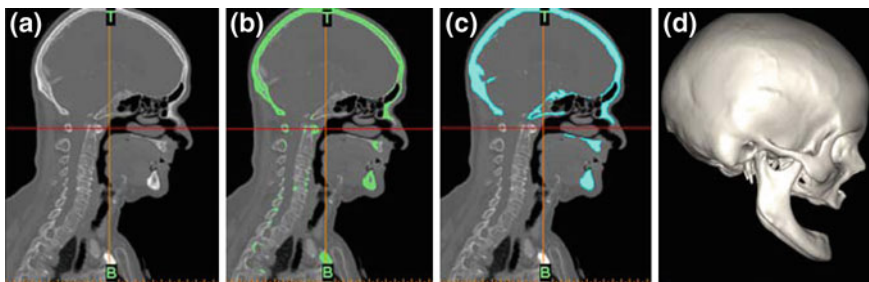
Main steps involved in the reconstruction of 3D model of human craniofacial as shown in the right sagittal view (a) computed tomography image of craniofacial (b) mask layer (green) creation (c) edited mask layer and (d) 3D model of craniofacial
